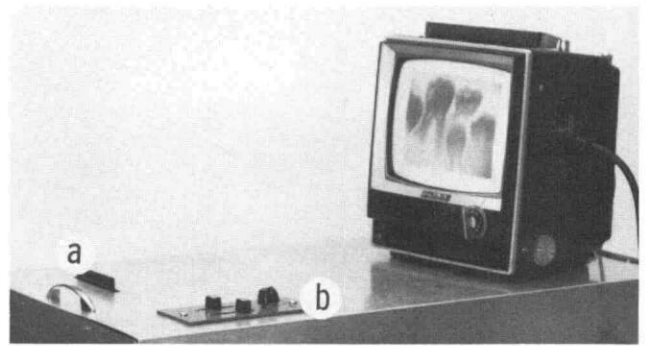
The radiograph electronic enhancement instrumentation, with (a) film holder; (b) variable controls, which the dentists adjusted for enhancing the diagnostic value of the film; and the television monitor on which the dentists viewed the electronically enhanced film.
